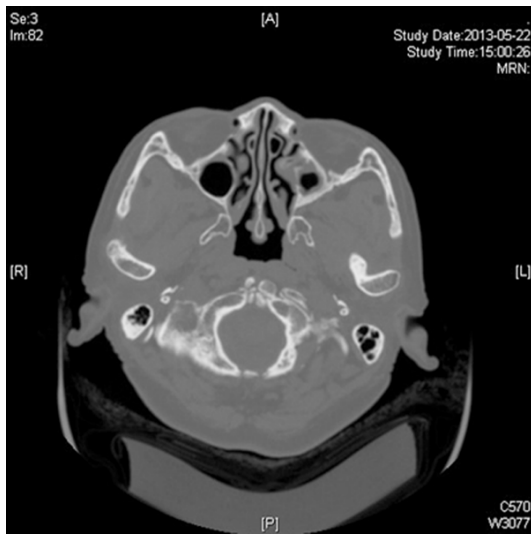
Preoperative CT scans. Axial CT scan showing the bony masses arising from the both sides of condylar surface (arrow).
